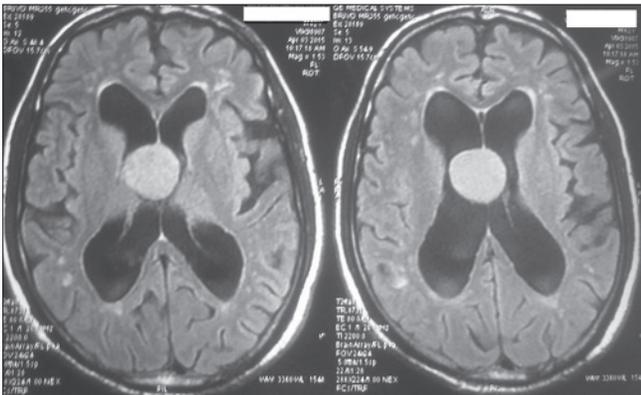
Magnetic resonance imaging brain axial T1 (WT)
